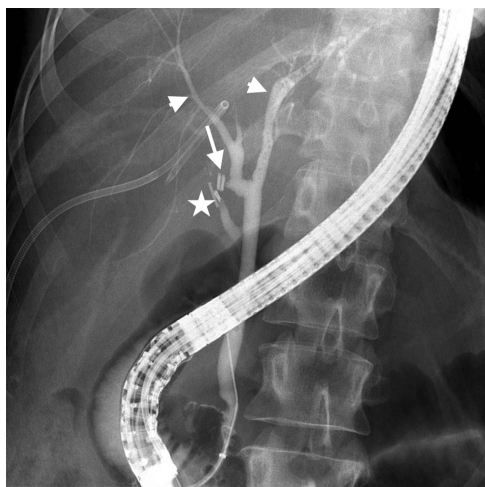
Frontal radiograph of the abdomen during endoscopic retrograde cholangiopancreatography demonstrating contrast in the left and right anterior hepatic ducts (arrowheads). Note the surgical clips on the cystic duct (star), and at the site of the right posterior sectoral duct (arrow). Lack of visualization of the leak and the right posterior ducts due to clipping.
